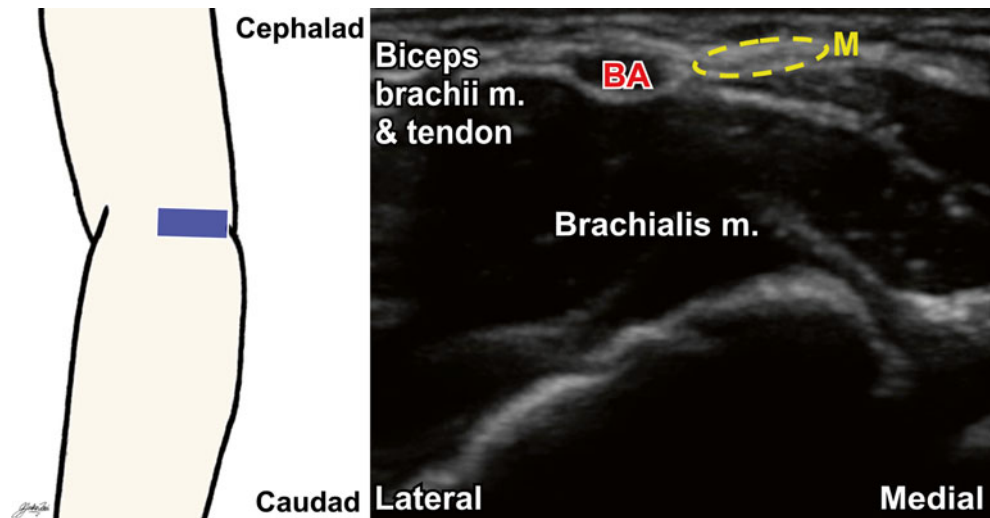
Ultrasound image of the median nerve at the antecubital fossa. *BA* brachial artery, *M* median nerve
